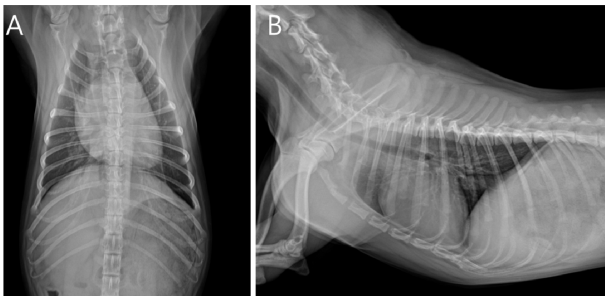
Thoracic radiography of this case. A: Ventrodorsal projection of thoracic radiography revealed typical reverse ‘D’ shape right cardiac enlargement with prominent main pulmonary artery bulging and under-circulated lung fields. B: Right lateral projection of thoracic radiography revealed cardiomegaly (4 intercostal spaces) with increased cardiac contact to the sternum and dorsal displacement of trachea enlargement.
